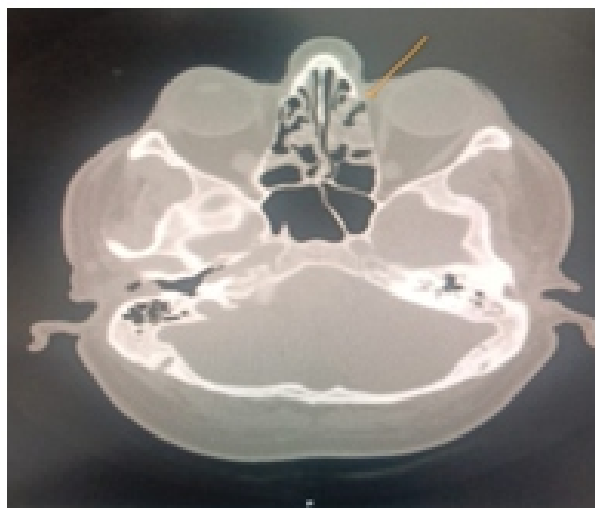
Partial opacification of bilateral ethmoidal air cells on CT
